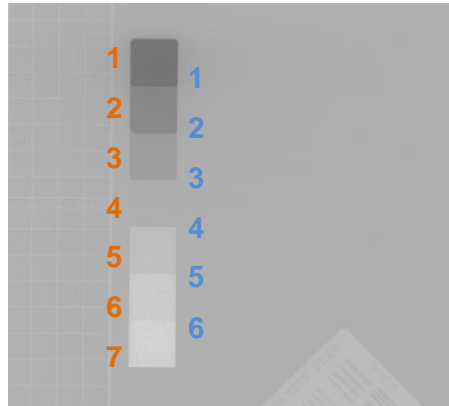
X-ray test pattern.
